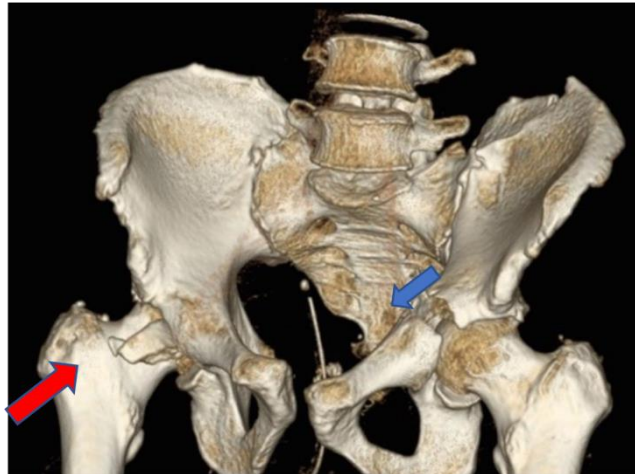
Figure I (Case One): 3-D CT pelvic re-construction antero-posterior view showing pubic symphysis disruption >2.5cm and a complete fracture through the left superior pubic ramus (blue arrow) and left iliac crest. A posterior dislocation of the right hip with a fractured posterior acetabular wall (red arrow) can also be seen.
